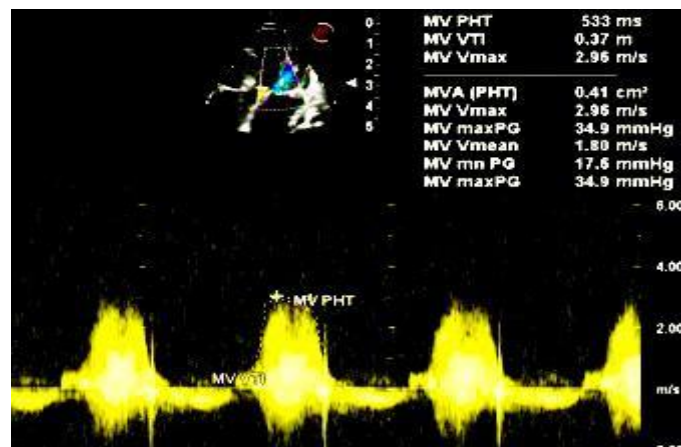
Continuous wave doppler analysis across the mitral valve revealed a mitral valve area of 0.41 sqcm by pressure half time. The peak and mean gradient was 34.9/17.6 mmhg.
